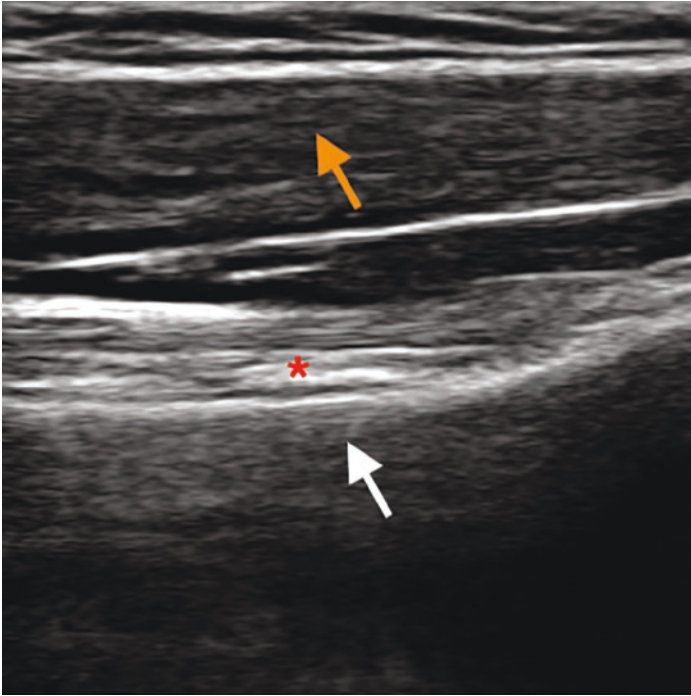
Long-axis ultrasound image showing a normal biceps tendon (red *) running along the humerus (white arrow) and underneath the deltoid muscle (orange arrow)
